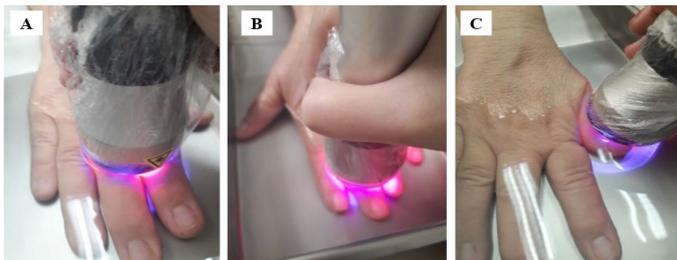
Application of the combined therapy Laser + Ultrasound with the metallic bowl. In A application of conjugate therapy in the proximal interphalangeal joints of the fingers. In B application of conjugate therapy in the distal interphalangeal joints of the fingers. In C application of conjugate therapy in the interphalangeal joint of the first finger.
